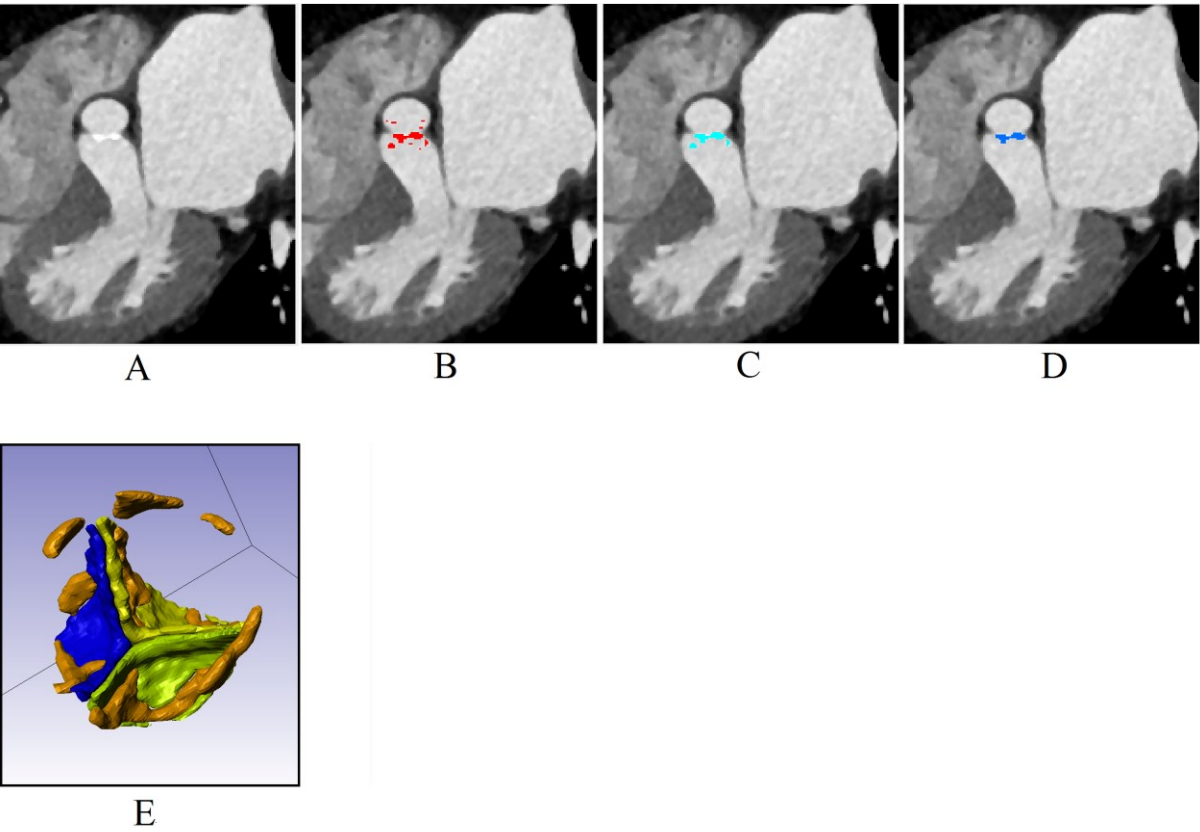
Medical CT images that have masks highlighted: No mask highlighted (A), Mask P1 (B), Mask P2 (C), Mask P3 (D) and Mask P4 with the leaflets (Mask L12) for context (E).
